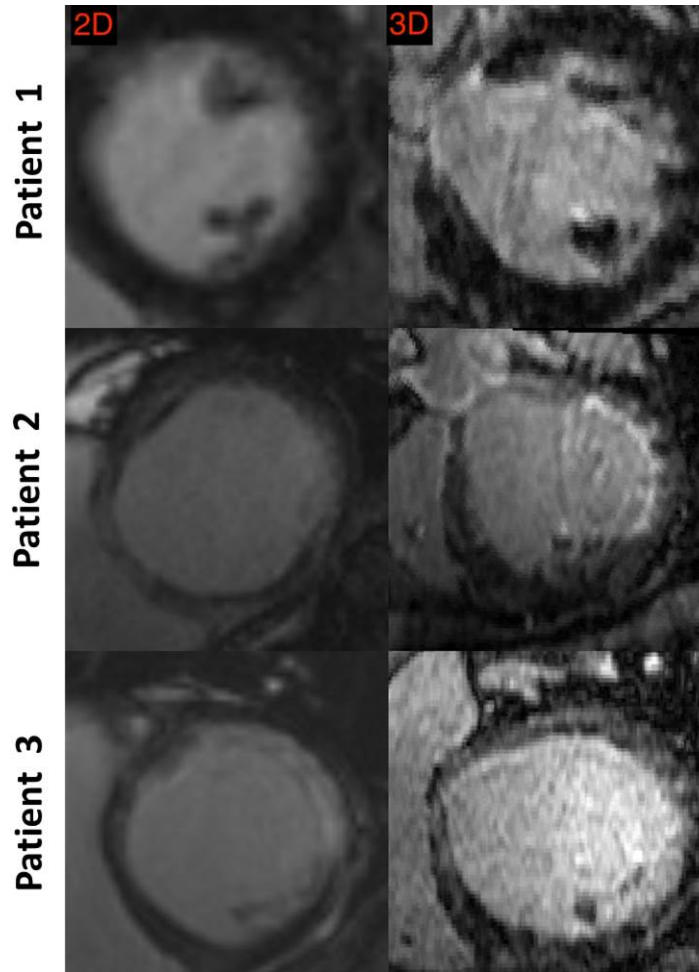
Comparison of single slice views from 2D (left column) and 3D (right column) LGE-MR images of three different patients (three rows). The 2D and 3D images approximately represent the same cardiac location. The resolution difference even in the SAX view can be seen from the single slice SAX view of 2D and 3D LGE-MR images. The 2D LGE-MRI has lower resolution due to the partial volume effect.
